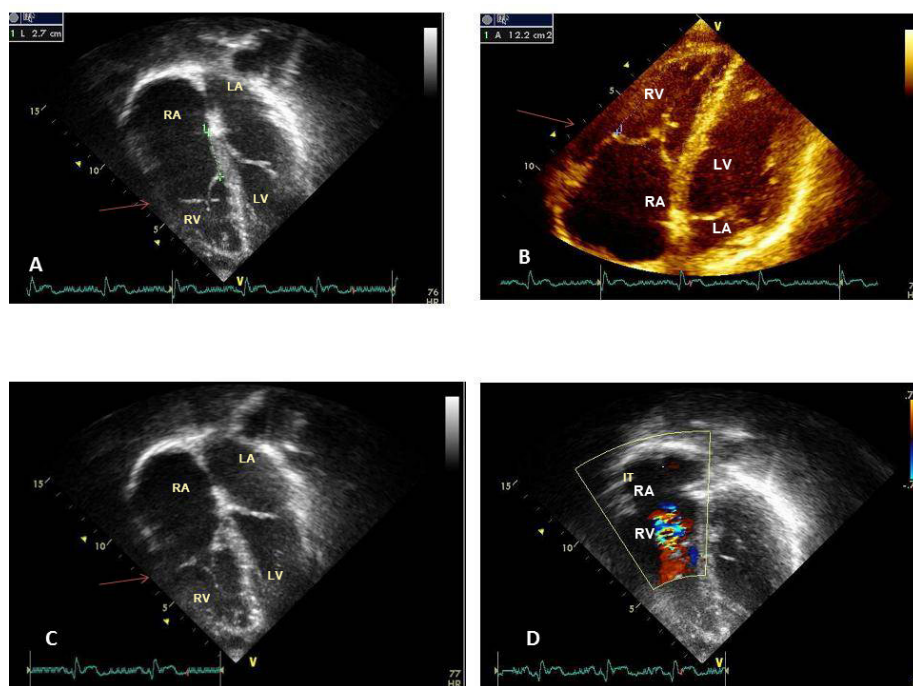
Echocardiogram shows, in the 4-chamber subcostal section, the septal and posterior valves sitting below the atrioventricular valvular plane, but with good coaptation in A, B, and C, and discrete tricuspid valve regurgitation in D. RA: right atrium; LA: left atrium; RV: right ventricle; LV: left ventricle.
